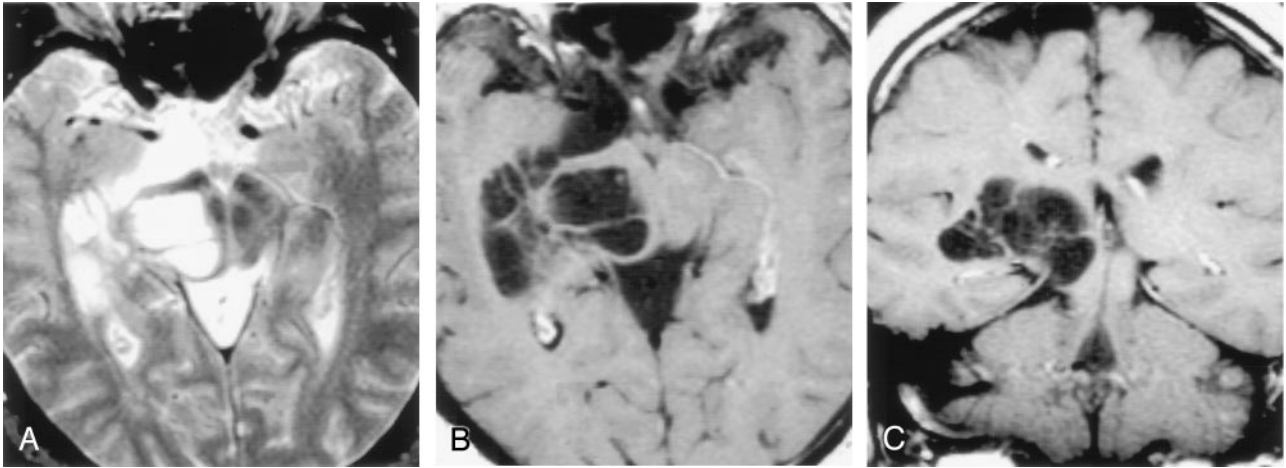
Axial T2-weighted (A), postcontrast axial T1-weighted (B), and postcontrast coronal T1-weighted (C) images obtained in a 46-year-old man with headaches show a nonenhancing multiloculated cystic mass in the right midbrain, thalamus, and right medial temporal lobe. The cysts follow CSF signal intensity on all pulse sequences and do not enhance. Follow-up imaging 13 years later showed no change. Biopsy proved pial-lined giant perivascular spaces.
